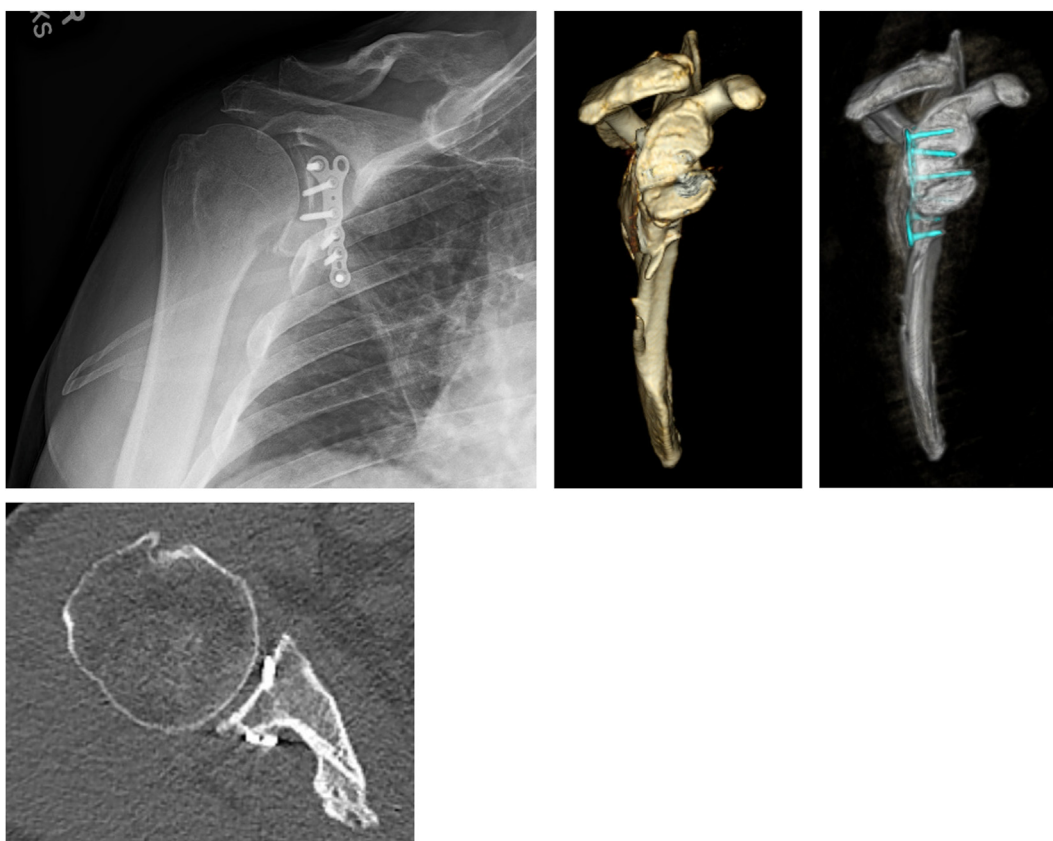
Grashey radiograph, axial CT, and CT 3D reconstructions demonstrate glenoid malunion with intra-articular extension of multiple screws. 3D, three dimensional; CT, computed tomography.
